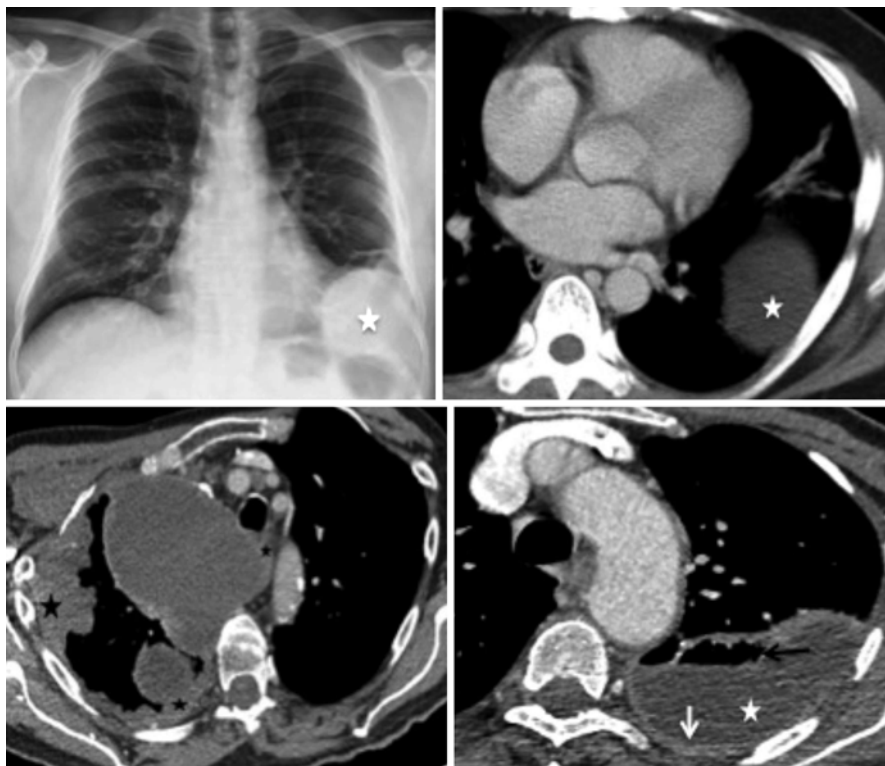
Complex pleural effusion. *Top panel* shows a rounded well-defined opacity in right costophrenic angle that is proven to be of uniform fluid attenuation on CT (*white star*). Appearances are that of a loculated fluid collection, giving rise to a “pseudotumor.” *Bottom left* is a case of mesothelioma with irregular nodular pleural masses (*black stars*) and loculated effusion and *bottom right* is a loculated effusion with pleural thickening and enhancement (*white arrow*) and air pockets secondary to an empyema. There is a pleural fluid collection (*star*) with air fluid level (*black arrow*) and pleural thickening (*white arrow*) in keeping with an empyema
